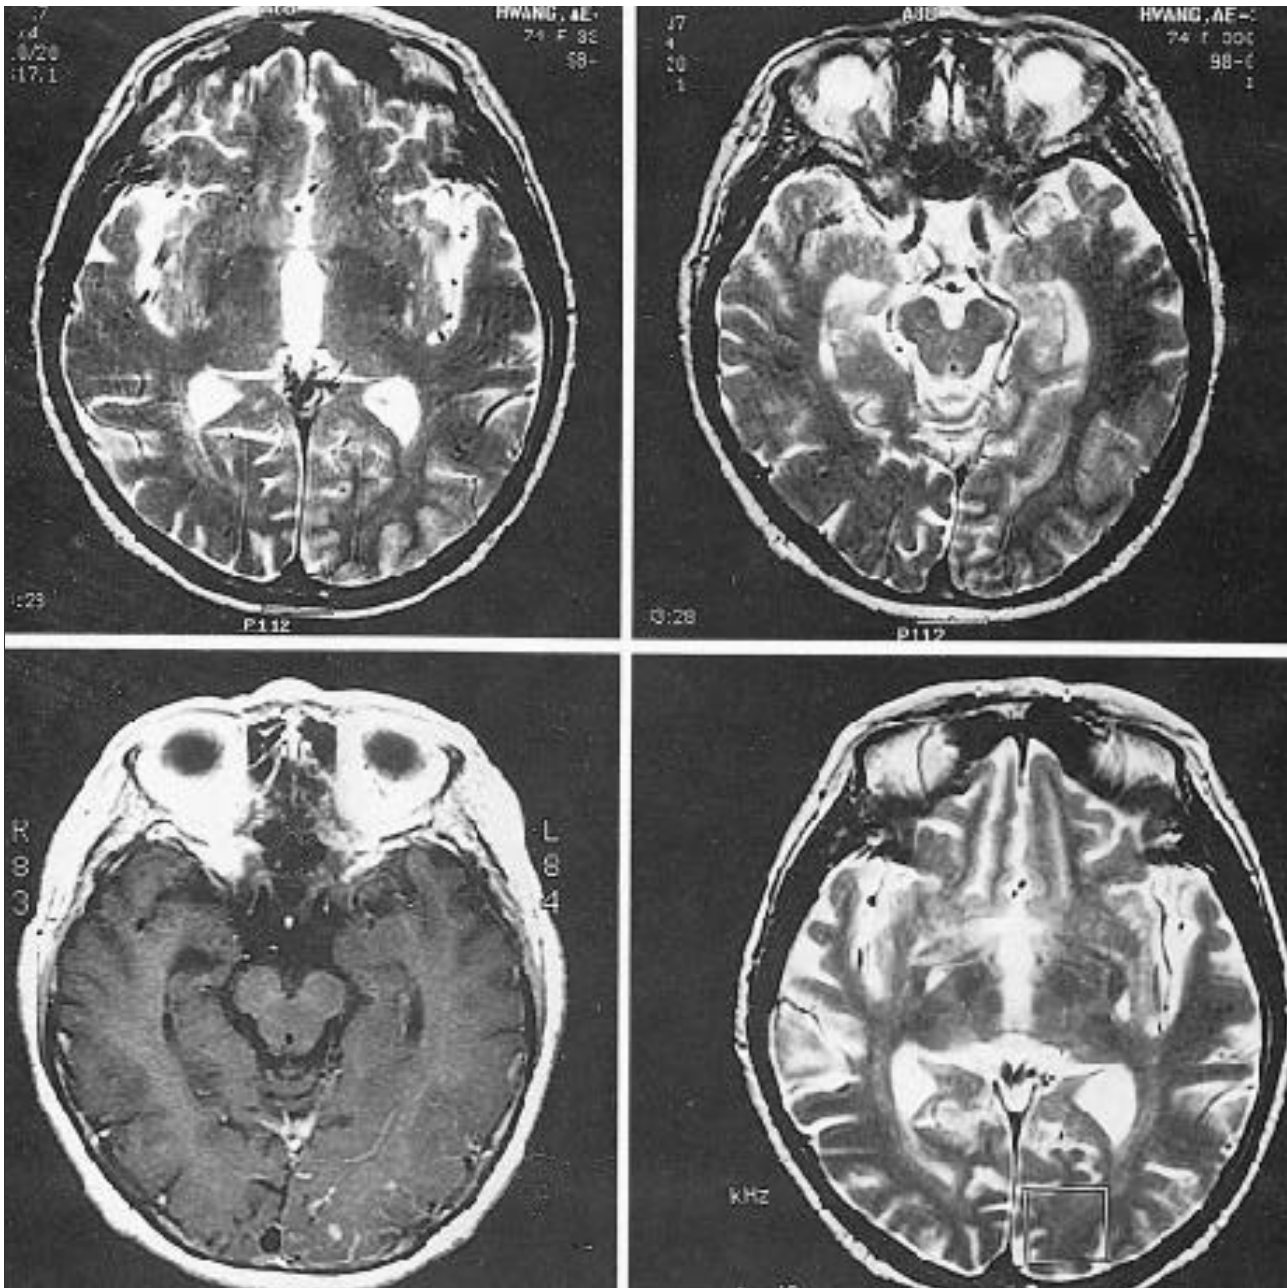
Axial brain MRI scan. Increased signal intensity in T2WI(A, B) and increased vascular enhancement(C) are noted in left occipital area during non-convulsive seizure attack. One month after seizure onset, the clinical seizure was controlled and the EEG had no more ictal, interictal discharge. In follow up T2W MRI after seizure control(D), there was no more signal abnormality.
